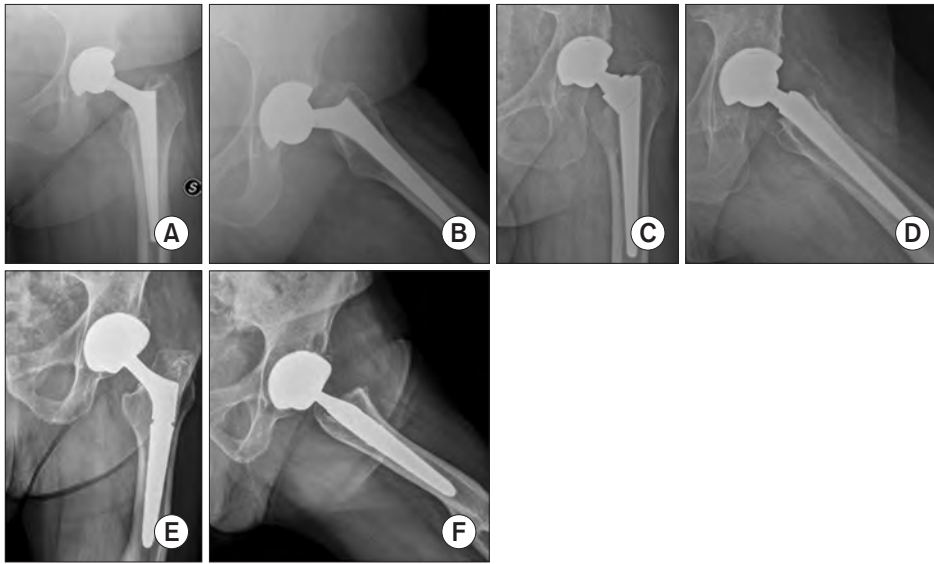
Anteroposterior and axial x-rays of the 3 implants: Wagner Cone (A, B), Alata Acuta (C,D), and Modulus (E, F).
